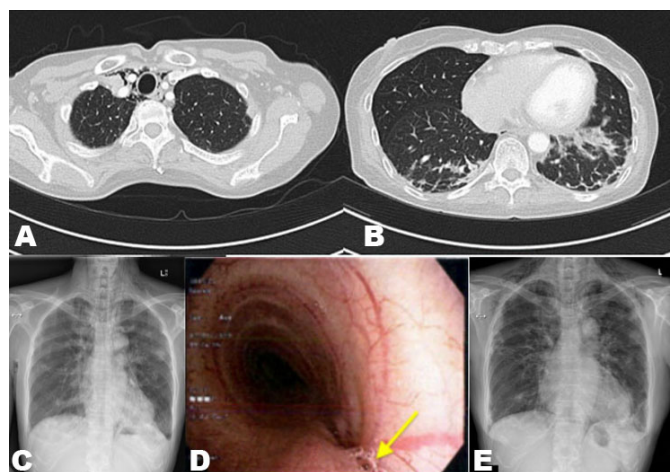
(A) CT chest: Multiple peripheral patches of consolidation are seen in both lungs. Small area of consolidation is also seen involving the inferior aspect of the posterior segment of left upper lobe of lung. Subsegmental atelectasis is seen involving both lower lobes basal segments; (B) CT chest: There is significant pneumomediastinum; (C) CXR: New extensive pneumomediastinum, subcutaneous surgical emphysema in the lower neck and left supraclavicular fossa, and new left lower lobe pulmonary infiltrate; (D) Bronchoscope: Tracheal wall defect at 5 o'clock position likely causing pneumomediastinum and subcutaneous emphysema in patient (yellow arrow); (E) Repeat CXR one month later: There is surgical emphysema over the chest wall extending to the neck with pneumomediastinum and no pneumothorax. There are some increased peribronchial lung markings peripherally in the right mid and at both lung bases particularly the left.
